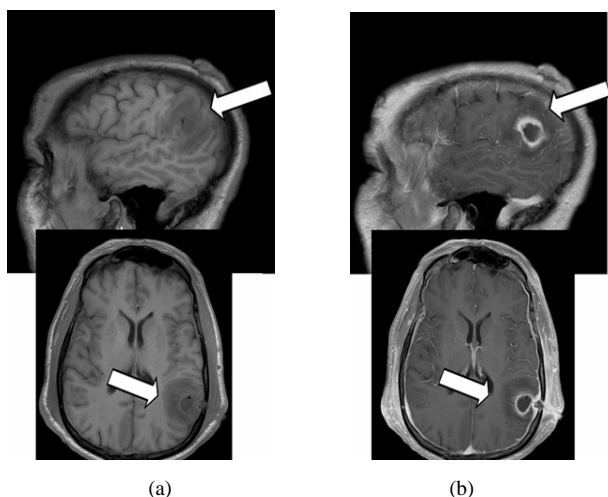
(a)-(b) MRI T1 pre and post contrast. Intracranial infection with diffuse meningeal thickening and enhancement, $13 \times 16 \times 14$ mm left parietal ring enhancing fluid collection with adjacent vasogenic edema most consistent with abscess.
